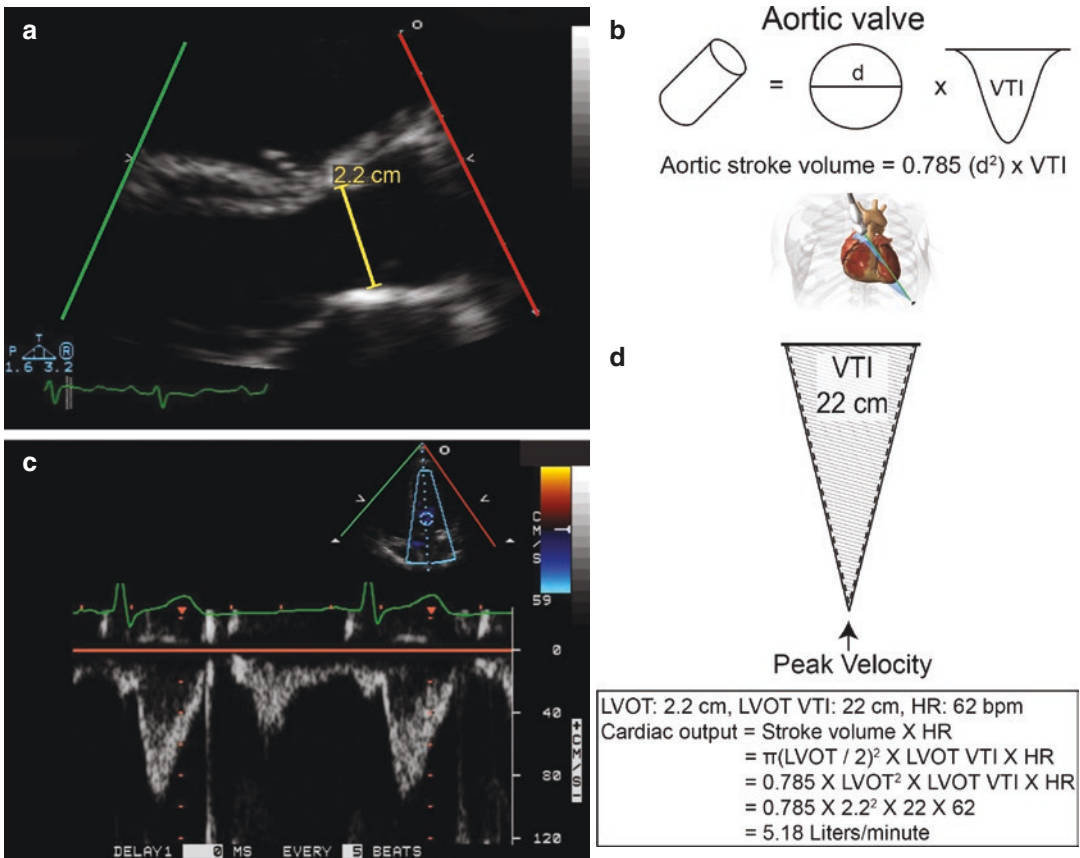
Cardiac output (CO). Calculation of CO involves (a) measurements of the annulus diameter (d) in a zoom of the left ventricular outflow tract (LVOT) from the parasternal long axis view. (b) Formula to calculate CO is shown (c, d) the velocity of the LVOT is obtained from the apical five-chamber view. (d) Tracing the outline
